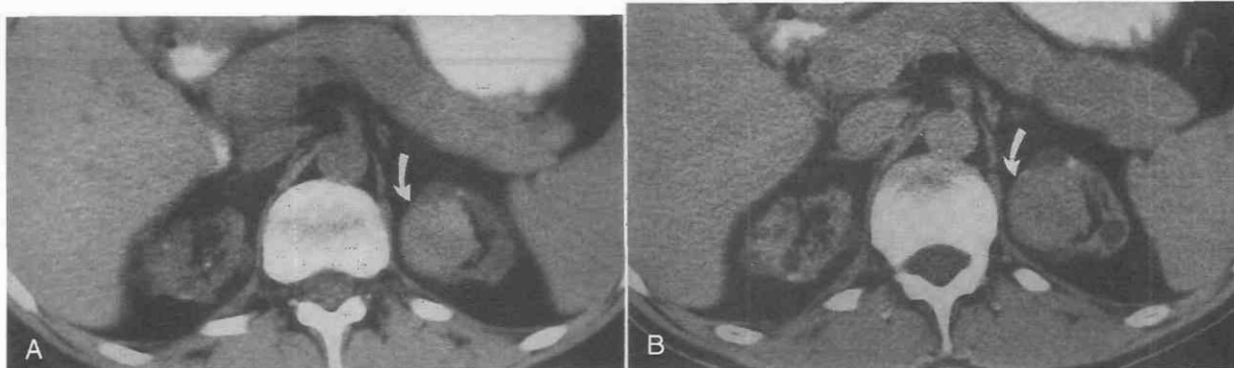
Acquired renal cystic disease with cyst hemorrhage in a 41-year-old man with gross hematuria. *A*, An unenhanced CT scan shows a 3.8-cm high-density (44 HU) mass (arrow) in the upper pole of the left kidney. *B*, After contrast enhancement, the attenuation value of the mass (arrow) was 43 HU. Multiple bilateral fluid-density cysts are also present. The mass resolved completely on a follow-up CT scan obtained 3 months later, suggesting a hemorrhagic cyst that had ruptured into the collecting system. (From Levine E, Slusher SL, Grantham JJ, Wetzel LH: Natural history of acquired renal cystic disease in dialysis patients: A prospective longitudinal CT study. *AJR Am J Roentgenol* 156:501-506, 1991.)
